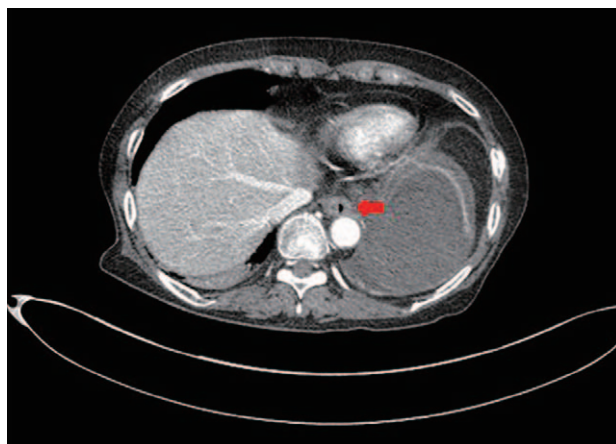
Chest computed tomography scans showed a diffuse wall thickening of upper esophagus (arrow).
